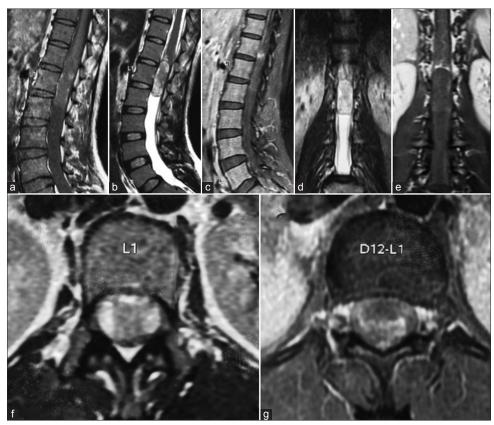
Magnetic resonance imaging showing (a)TI-weighted sagittal, (b)T2-weighted sagittal, (c) contrast-enhancedTI-weighted sagittal, (d) STIR sequence coronal images (hyperintense signal, suggestive of intralesional bleed), (e) contrast-enhancedTI-weighted coronal image (small rim of enhancement at the superior pole), (f)T2-weighted axial image, and (g) contrast-enhancedTI-weighted image at the superior pole (D12-LI level showing rim-enhancement)
